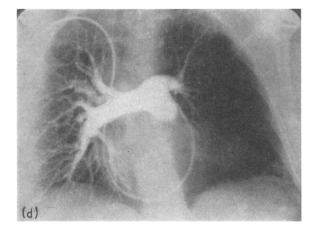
Case 5. (a) Chest radiograph on admission, 14 January 1967. Oligaemia of most of left lung. (b and c) Anterior and posterior scans, 17 January. Reduced perfusion of both left upper and left lower lobes. (d) Pulmonary angiogram showing small left pulmonary artery and branches, 30 January.
